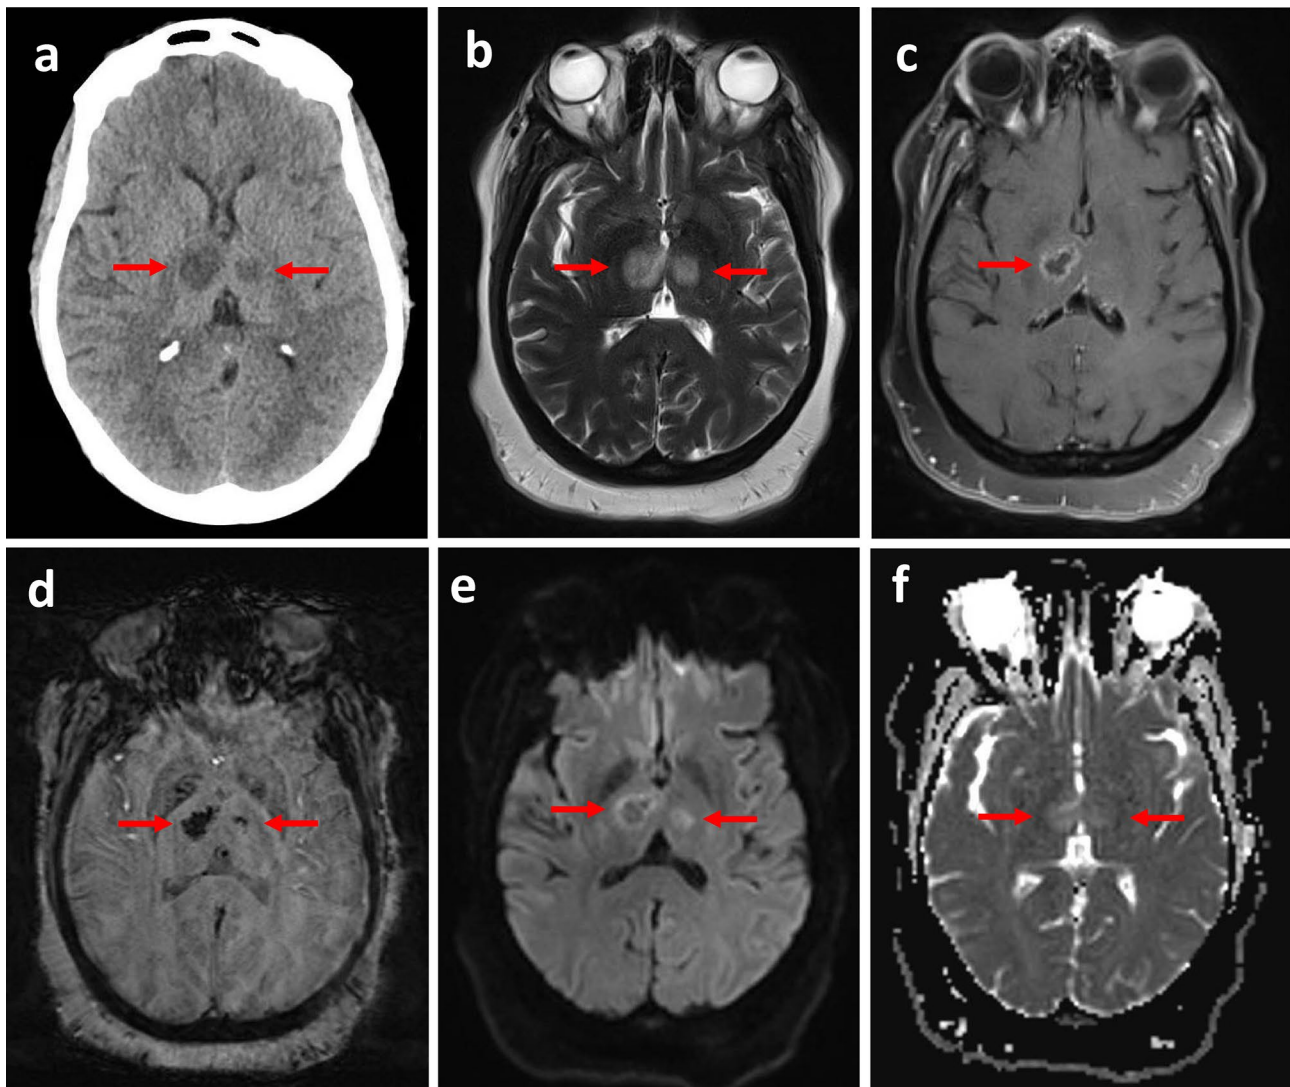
Initial non-contrast head CT (A) showing hypodensities in the bilateral thalami. Brain MRI on admission demonstrating bilateral thalamic T2 FLAIR hyperintensities (B) with rim enhancement on postcontrast T1-weighted imaging (C). Foci of blooming artifact
